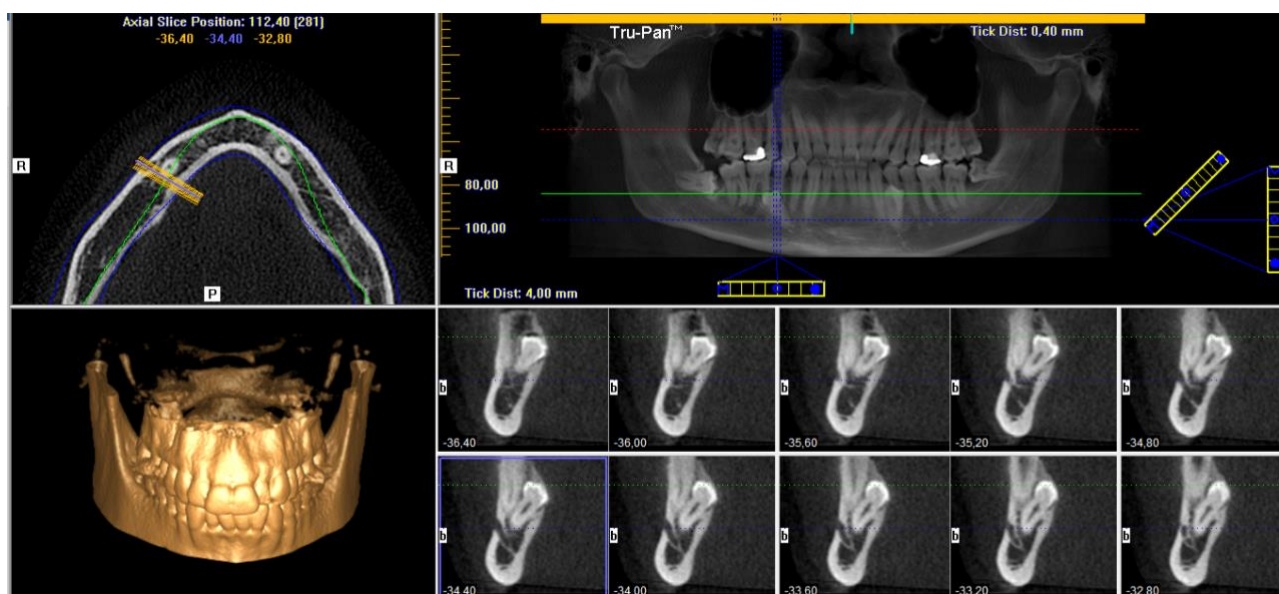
CBCT view of a supernumerary premolar (no contact with the mental foramen).
